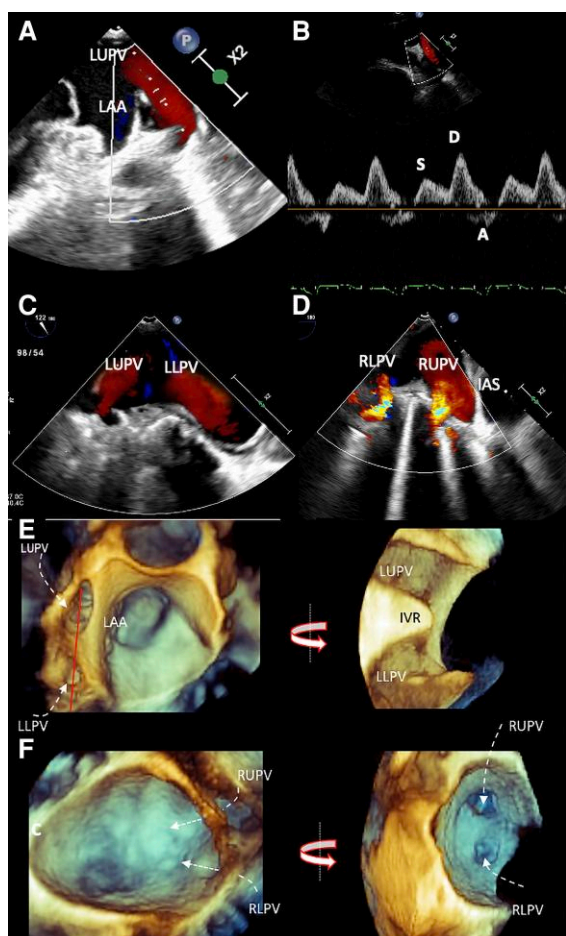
PVs by TOE. (A) Left upper PV, 60°, colour Doppler; (B) left upper PV, pulsed-wave Doppler; (C) left upper and lower PVs, 120°, colour Doppler; (D) right upper and lower PVs, 0° clockwise rotation; (E, F) the left and right PVs, 3D-rendered image.
